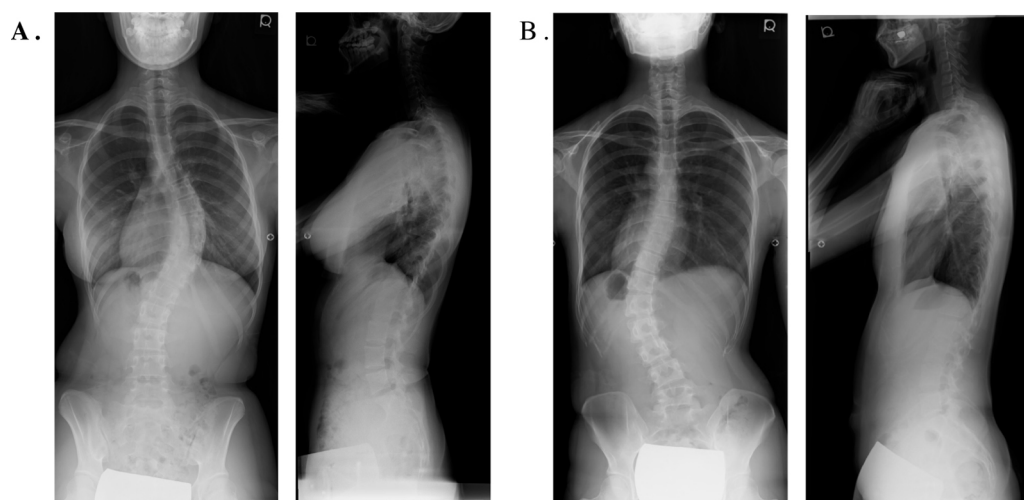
Typical radiographic images of AIS patients with a single curve. A: Single thoracic major curve (Lenke type 1), B: Single lumbar major curve (Lenke type 5).
